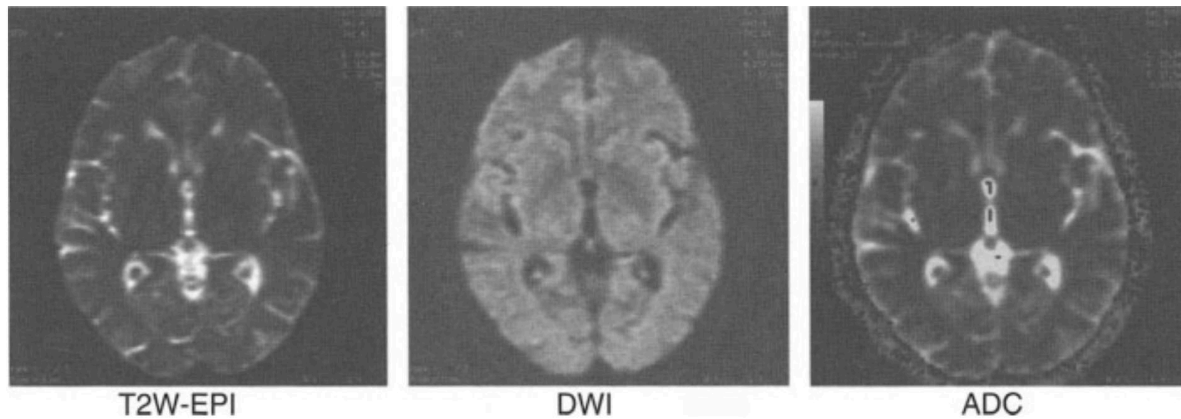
Diffusion Weighted Imaging. On the left, there is a T2-weighted EPI image without any diffusion-sensitizing gradient (the $b=0$ image). On the image in the middle, a diffusion-sensitizing gradient is added making the ventricles appear dark because of signal loss due to diffusion of spins in CSF (DWI). On the right, there is the calculated ADC map that quantifies the magnitude of diffusion as described in the text [11].
